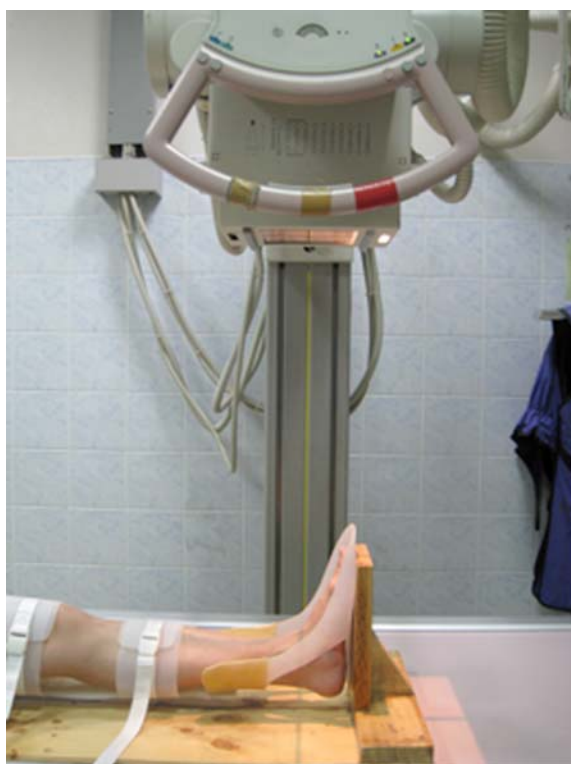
The picture demonstrates the radiographic method to obtain a supine anteroposterior ankle film with the specially designed splint
